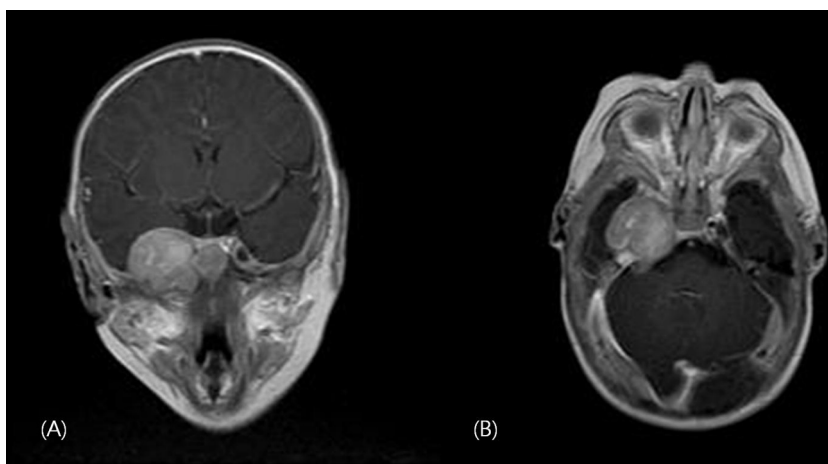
Gadolinium-enhanced T1 weighted magnetic resonance images of the brain. Axial images (A) and coronal images (B) show a well enhancing outbulging mass of approximately 3 cm size in the right petrous bone, compressing the right temporal lobe.
